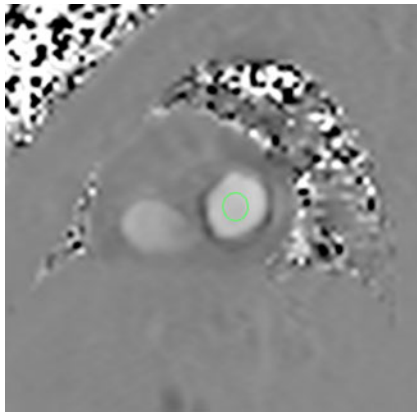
Measurement of transmitral flow. Phase-encoded MRI obtained with a phase-contrast sequence shows a region of interest placed at the centre of the mitral orifice. The transmitral flow curve is obtained from this region of interest
